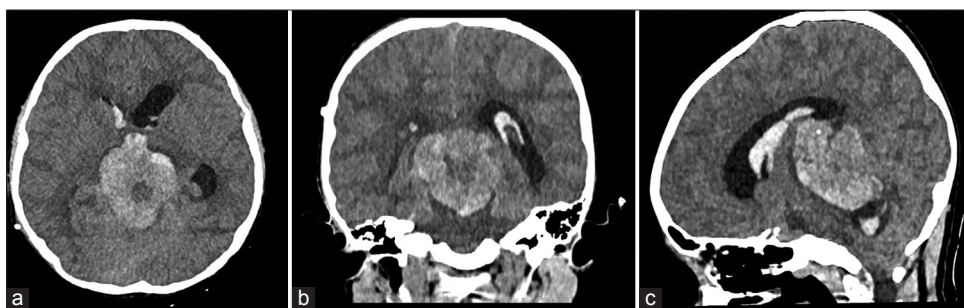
Postshunt computed tomography showed a massive hyperdense lesion indicating intratumoral hemorrhage in the lateral, third, and fourth ventricles with extensive perifocal edema. (a) Axial view, (b) Coronal view, (c) Sagittal view.
